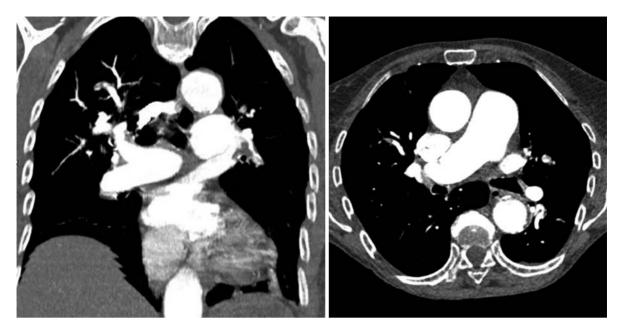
An 84-year-old woman with dyspnea and a BMI of 21.6 kg/m², referred for CTPA. CTPA shows patterns of acute and chronic pulmonary embolism. Acquisition was obtained with a 16×0.6 mm beam collimation, 110 kVp and an AEC device. The reference effective mAs value reflecting the desired image quality is set at 100 mAs. The AEC device reduced this value to 44 mAs. The DLP for the entire acquisition was 99 mGy·cm, and the corresponding effective dose was 1.5 mSv, a dose no higher than that of a chest CT for screening for lung cancer
